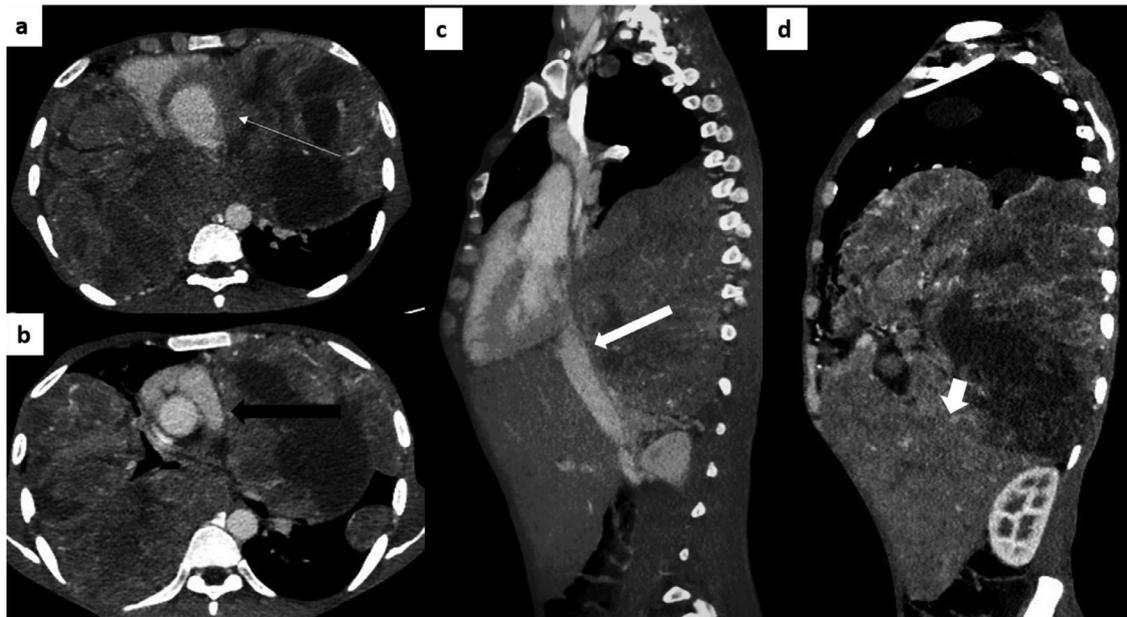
Primary monophasic synovial sarcoma of lung (A, B) axial and (C, D) sagittal contrast enhanced CT show few heterogeneously enhancing masses with areas of necrosis in bilateral hemithorax, with indistinct plane with heart (thin white arrow), abutting the main pulmonary artery (black long arrow) and displacing the abdominal aorta anteriorly (white long arrow), indenting the liver inferiorly (white short arrow).
